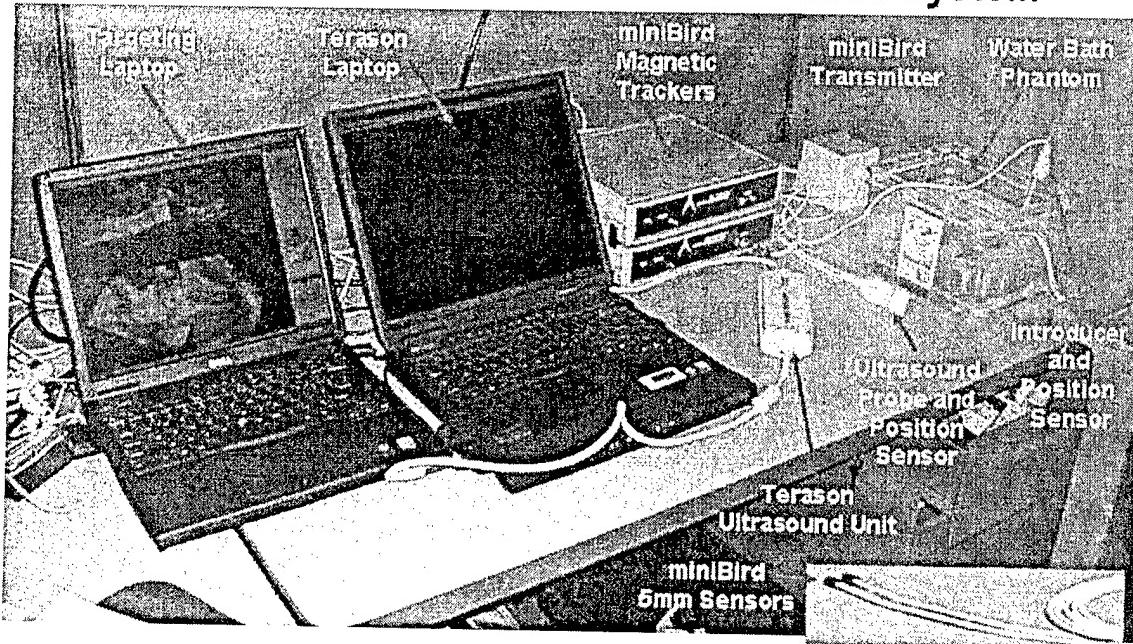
Current smart catheter guidance and placement demonstration prototype system, including the Terason 2000 portable ultrasound unit and ultrasound probe; the Ascension miniBird magnetic trackers, transmitter, and 5-mm position sensors; and ultrasound laptop and targeting laptop. Ultimately, all software and necessary interfaces will be integrated onto a single laptop or LCD for display.
